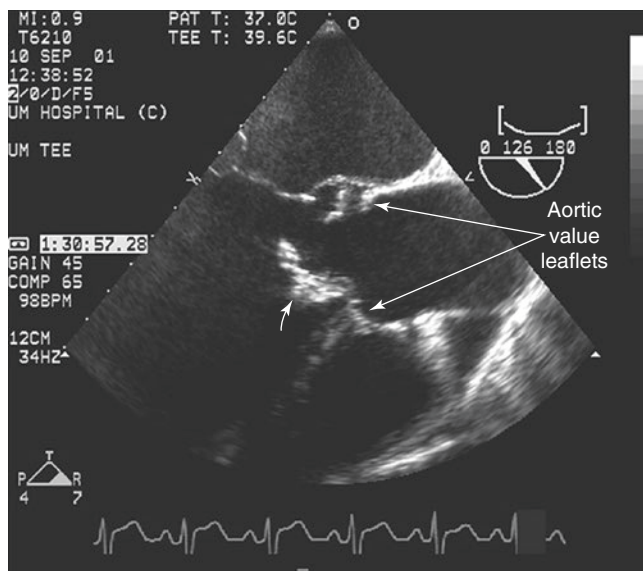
Transesophageal echocardiogram in a patient with aortic valve endocarditis and vegetations. Vegetations attached to the aortic valve leaflets (*arrows*) can be identified; their presence was subsequently confirmed by surgery. *LA* left atrium, *LV* left ventricle
